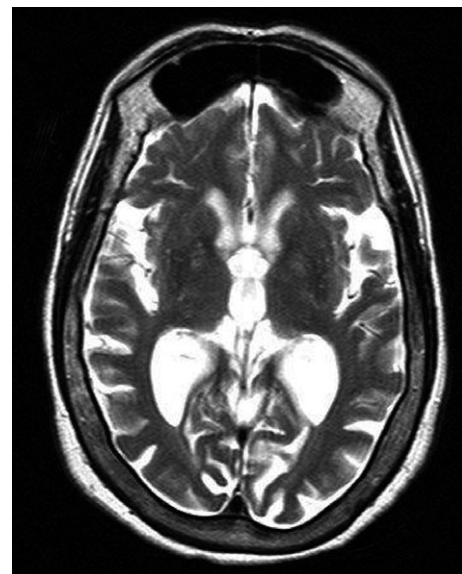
T2-weighted image MRI from case 1.
